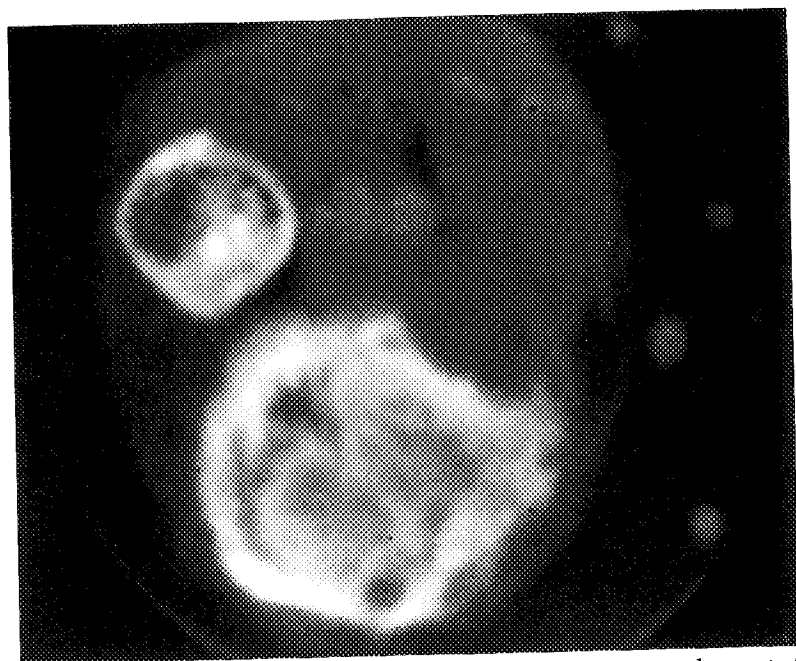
Computed tomographic scan of the left leg, showing involvement of the tibia with fibrous dysplasia. Note the areas of irregular contour and bony expansion.
